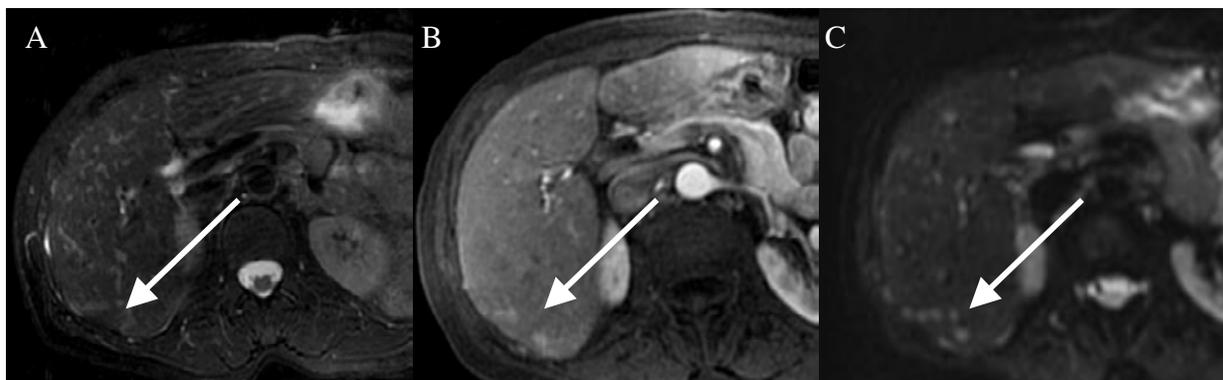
Small neuroendocrine metastases (arrows) are poorly visualized on FSE (A) and CE-LAVA (B) images. Note improved lesion conspicuity on DWI (C).
